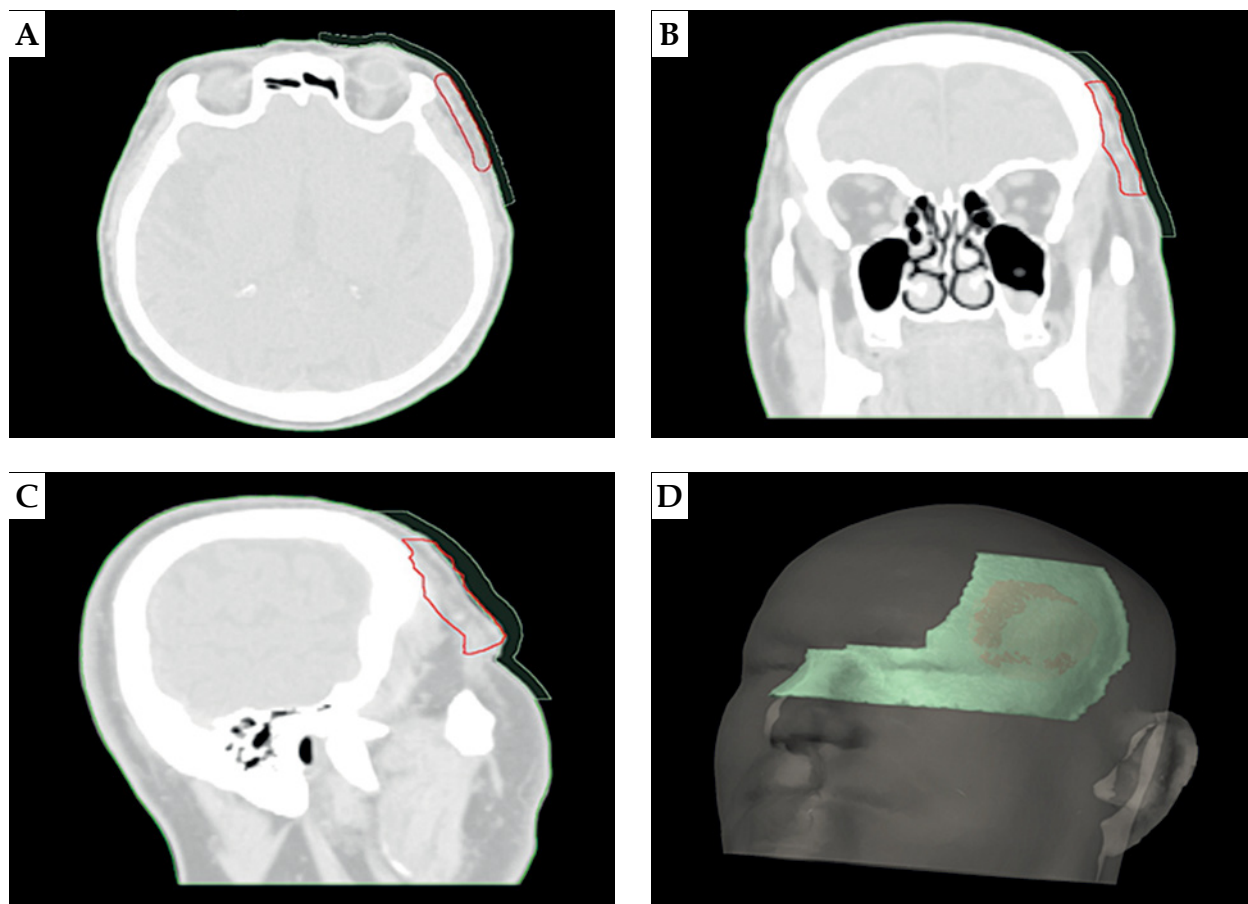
View of CT scan with applicator and target structure for A) transverse section, B) frontal section, and C) sagittal section. D) 3D view
